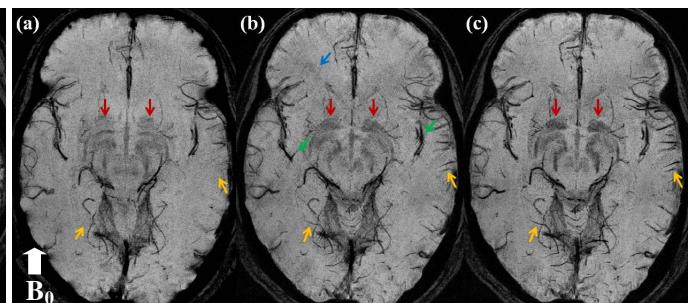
Axial images in open-type MRI by (a) SWI, (b) tSWI, and (c) SDWI.
